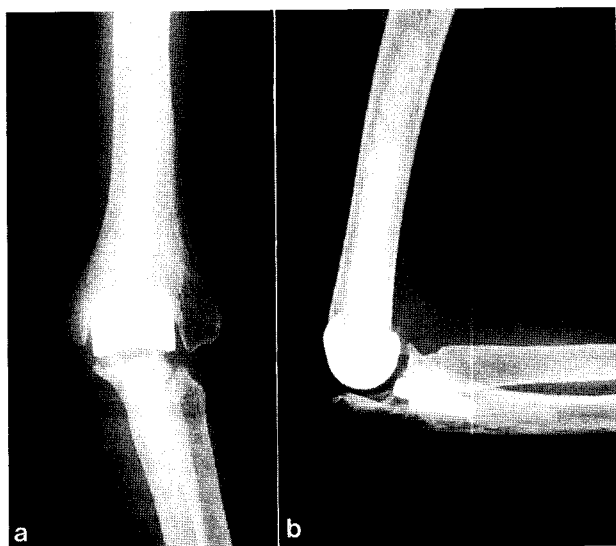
X-ray 6 years after total elbow replacement (TER). a: Antero-posterior view; b: Lateral view.
